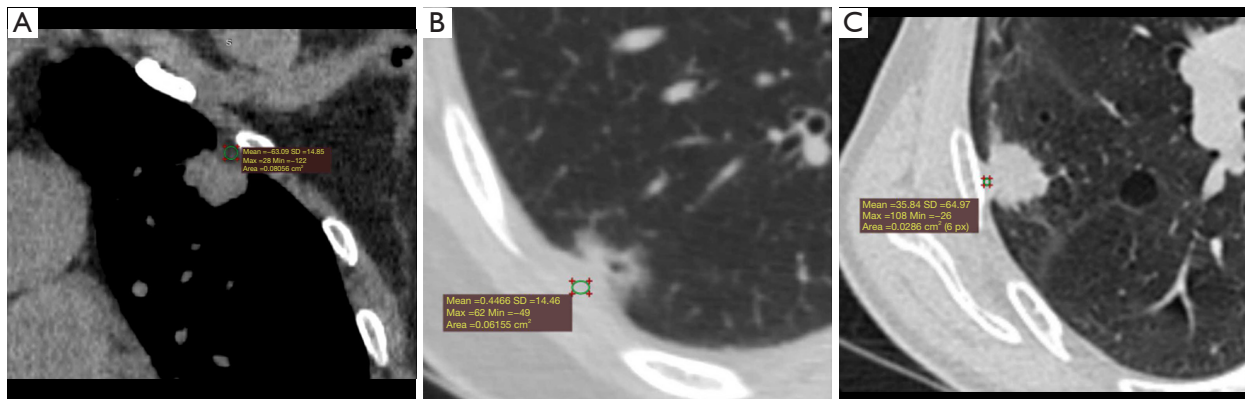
The density changes of the pleura in direct pleural contact type. (A) A 59-year-old female presented with solid nodule in the left upper lobe and fat density in the costal pleural indentation (Type C). (B) A 55-year-old female presented with mGGNs in the right lower lobe and water density in the costal pleural indentation (Type D). (C) A 64-year-old man presented with solid nodule in the right upper lobe and soft tissue density in the costal pleural indentation (Type E). SD in figures means standard deviation of CT value. CT, computed tomography; mGGNs, mixed ground glass nodules.
